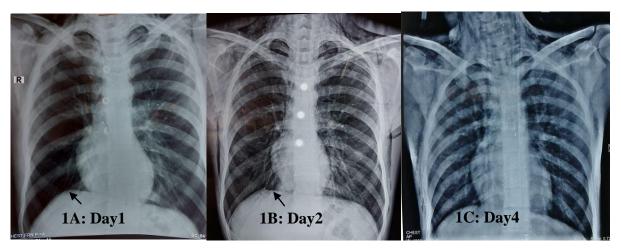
Serial chest X-rays of the patient. Note the pneumomediastinum in 1A and 1B (shown as arrow) which has resolved in 1C
